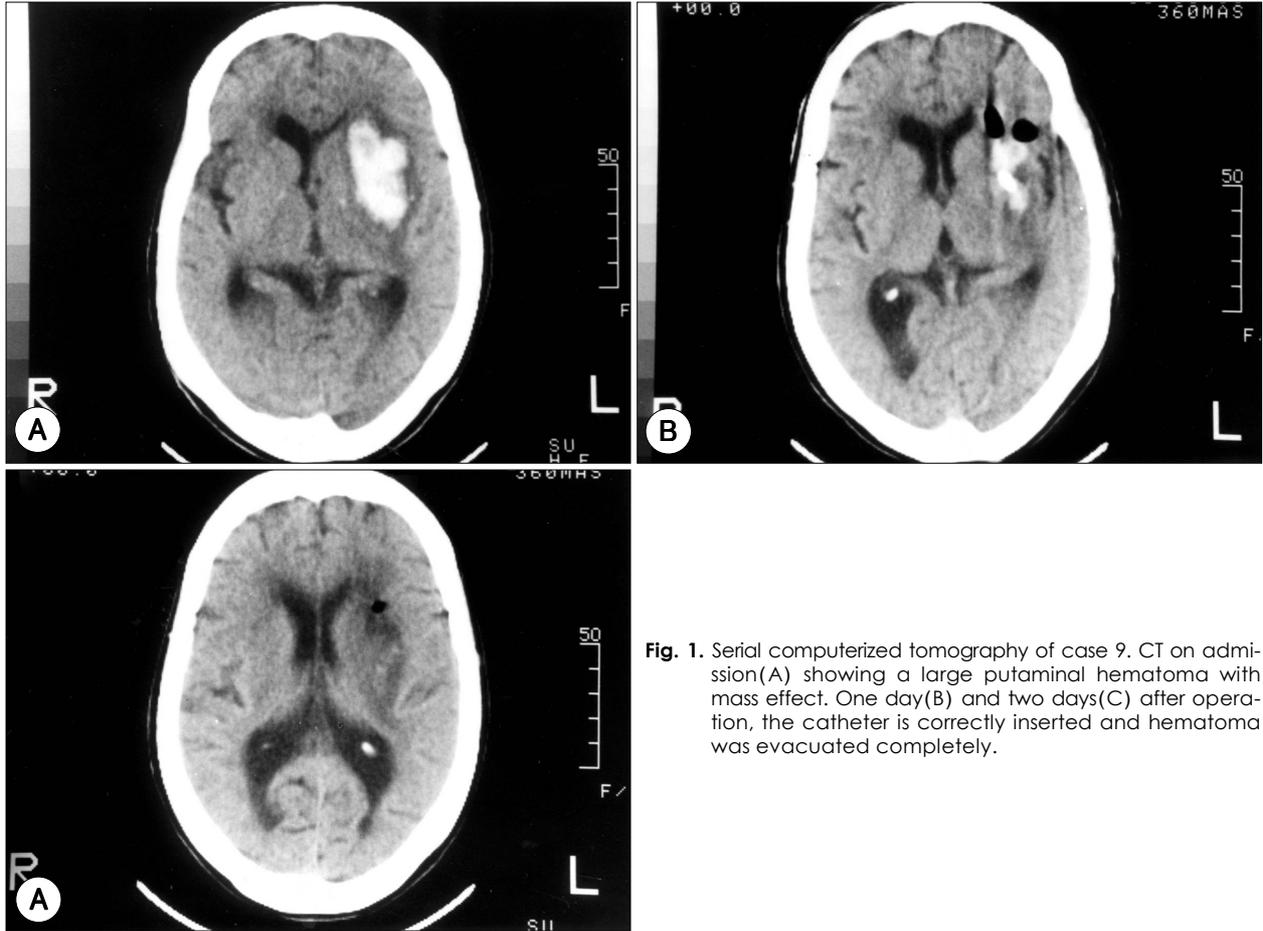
Serial computerized tomography of case 9. CT on admission(A) showing a large putaminal hematoma with mass effect. One day(B) and two days(C) after operation, the catheter is correctly inserted and hematoma was evacuated completely.
